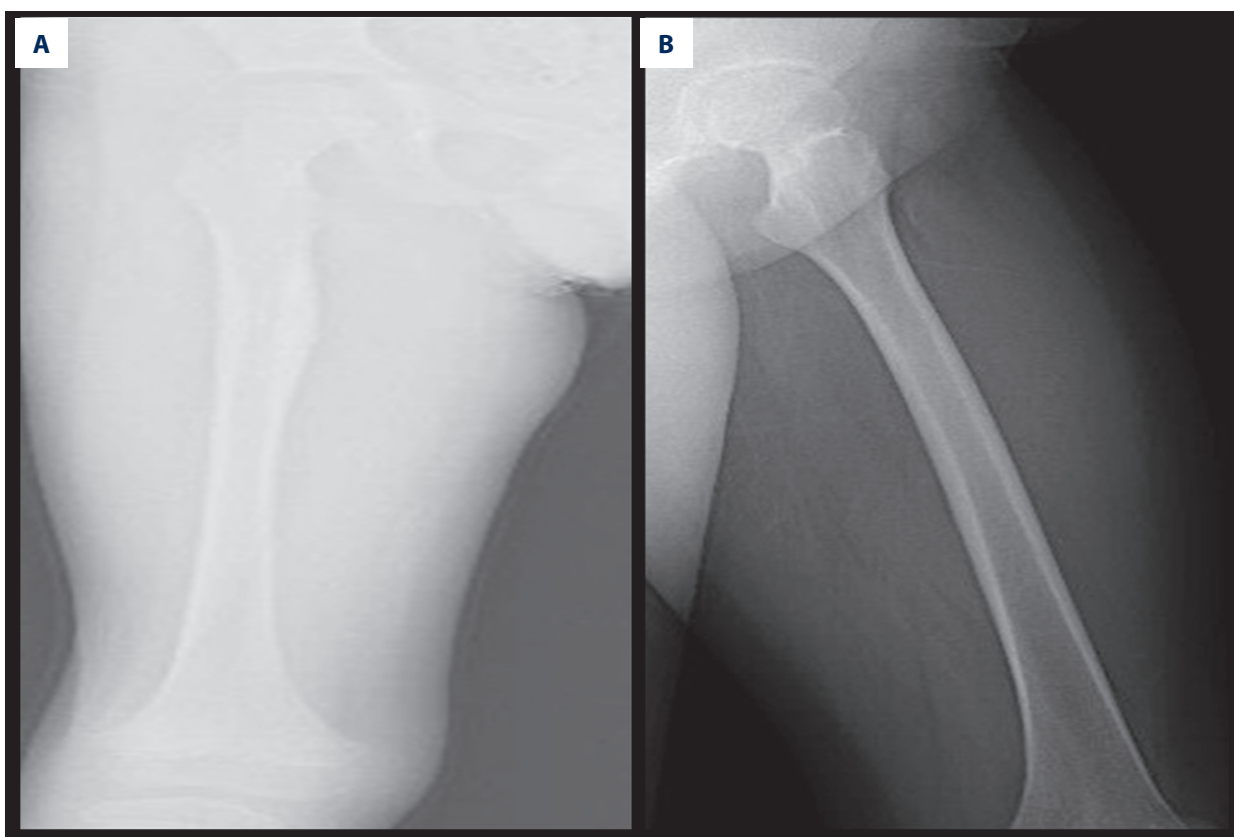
Postoperative anteroposterior (A) and lateral (B) radiographs of patients.
